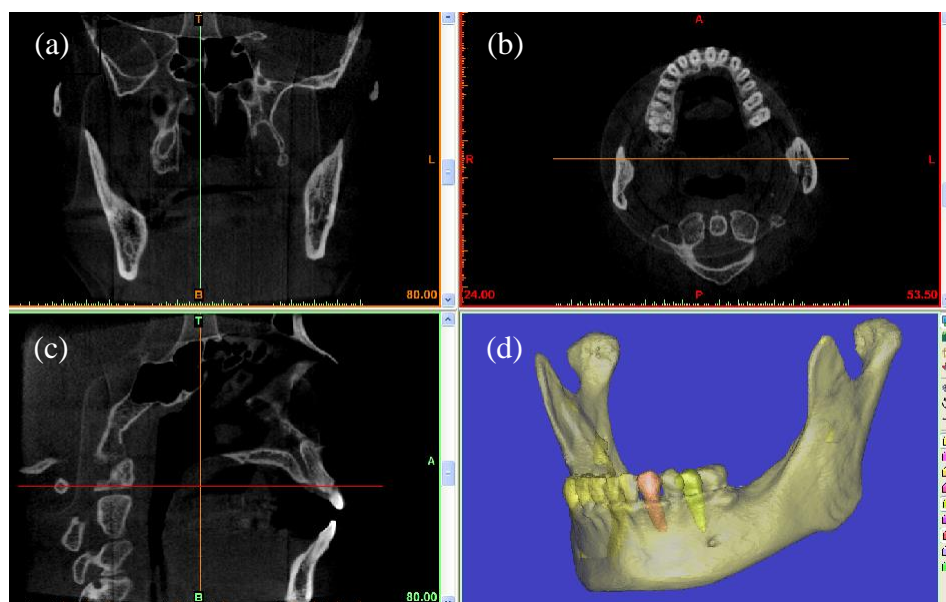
CBCT image shown in a MIMICS[®] window.
